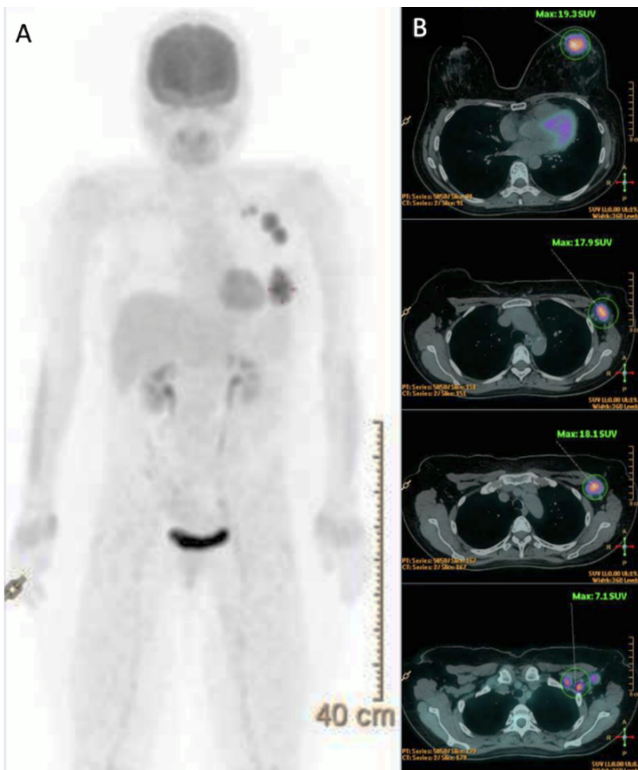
Whole-body positron emission tomography-computed tomography (PET-CT) (A: coronal 3D MIP PET image; B: axial fused PET-CT images) revealed a hypermetabolic mass in the left breast (SUVmax: 19.3) and left axillary lymph node enlargement at levels I and II (SUVmax: 18.1).
